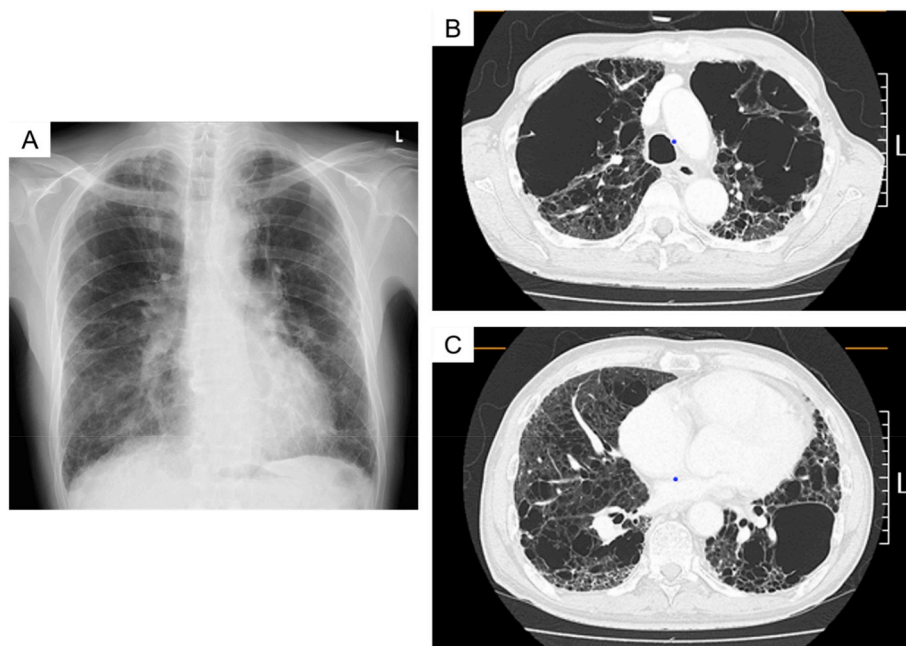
A: Chest X-ray showed both reticular infiltration at basal periphery of bilateral lungs and hyperlucency with reduction in pulmonary vessels at bilateral apices. B, C: HRCT revealed both emphysematous change with bullae at upper bilateral lobes and emphysematous change with peripheral reticular opacities at lower bilateral lobes.
